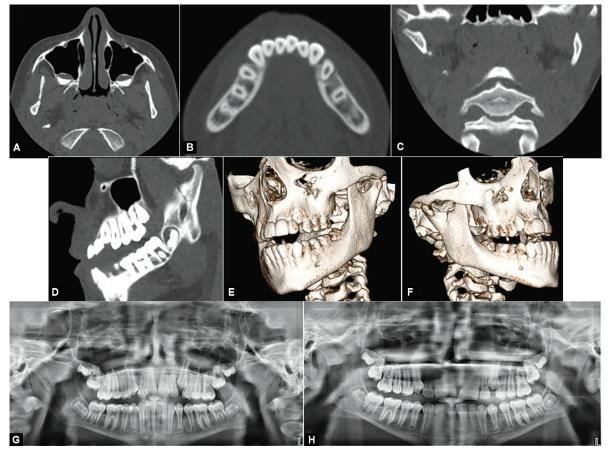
to F: Case presentation of a dislocated condylar neck fracture (Spiessl and Schroll, in an 8-year-old female patient. (A–C) Preoperative DVT scans demonstrating the angulated fracture of the right condylar neck (Spiessl and Schroll type IV).¹⁸ (D–F) Postoperative CT scans following ORIF using a preauricular extraoral surgical approach to the condylar region. Using short-acting muscle relaxants, a nerve stimulator is used to identify and preserve the facial nerve
